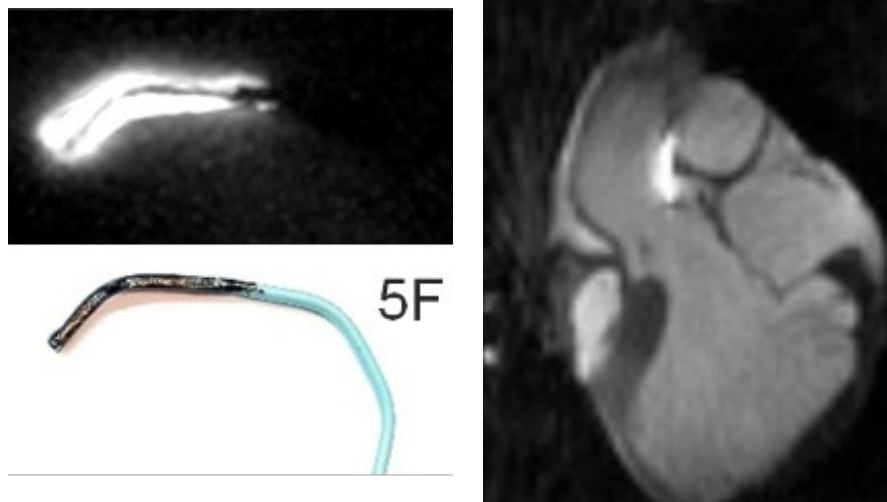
Left: MRI and photograph of a 5 French active tracking catheter with tip coil (black paint). Right: Real-time MRI of the insertion of the tracking catheter into the left coronary artery.
